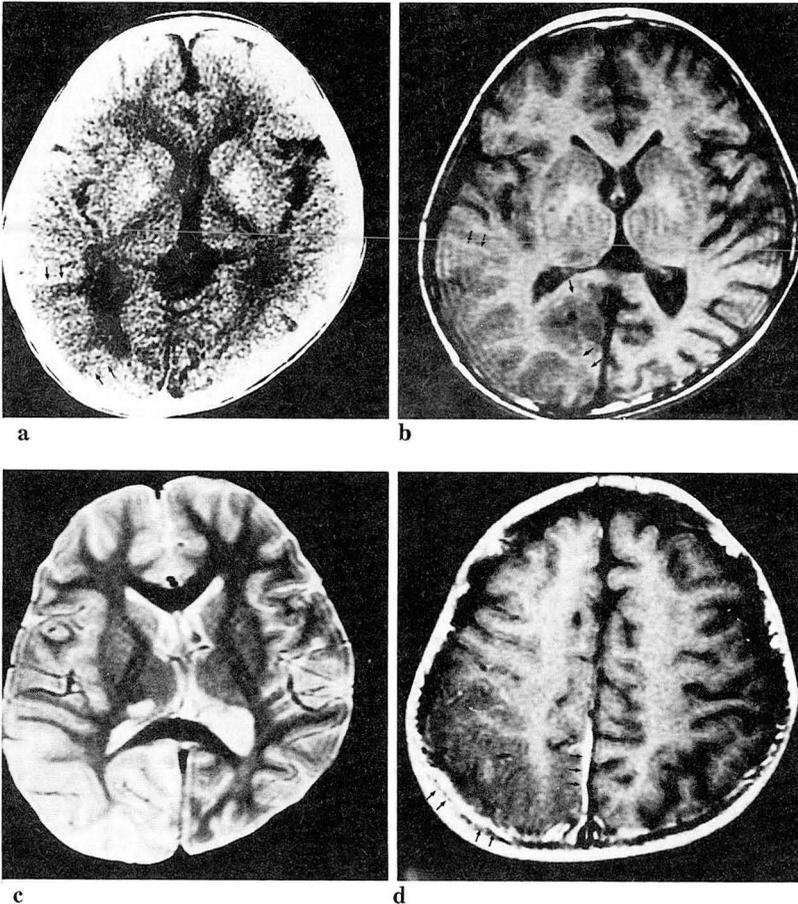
a. Axial non-enhanced CT scan shows bilateral basal ganglia calcifications and low density infarction in right parietal region (arrows).
